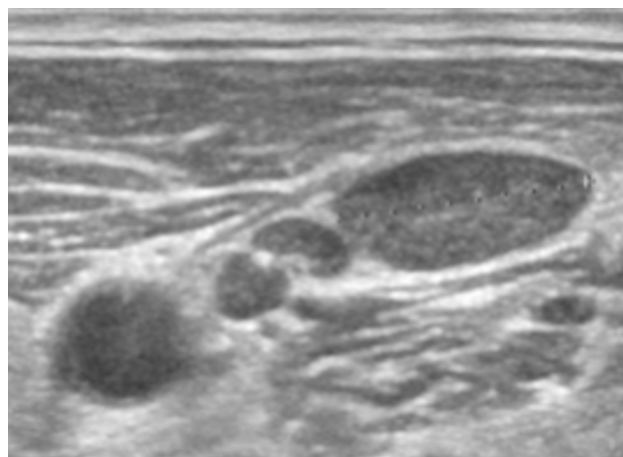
Ultrasound scan of the right neck showed approximately 1 cm lymph nodes. Short-to-long axis ratio was 0.42 with normal nodal hilus.
